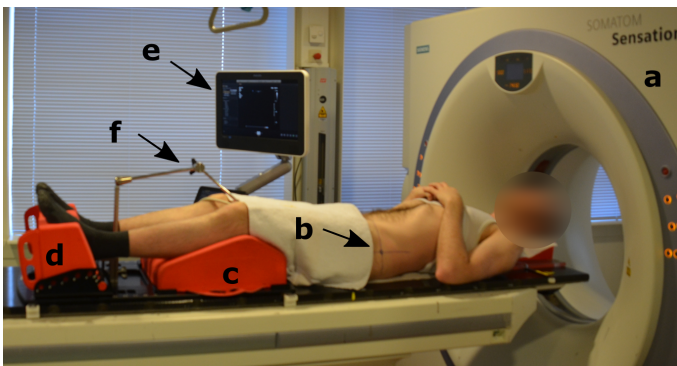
Volunteer mimicking the patient setup for CT and US volume acquisition: (a) CT scanner (b) Skin markers on the volunteer’s body for isocenter laser alignment. (c) Kneefix™2 (d) Feetfix™2 (e) EpiQ7 US system monitor (f) Mechanical arm with rotary knob for US probe fixation.
